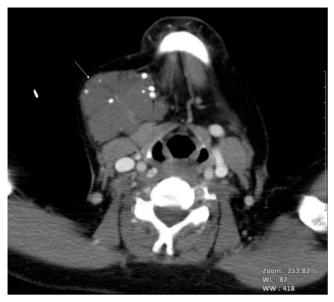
Contrast-enhanced axial CT showing a non-enhancing haemangioma (white arrow) containing several foci of calcification (black arrow) in the right submandibular space.
